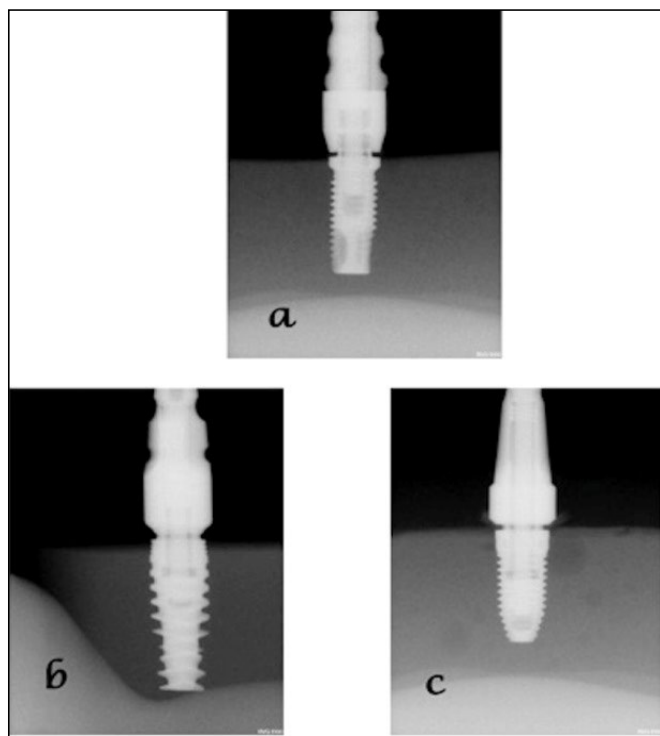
Radiographic images in 0° tube angulation with gap 0.5 mm: a) system B, b) system NA, c) system NR.
